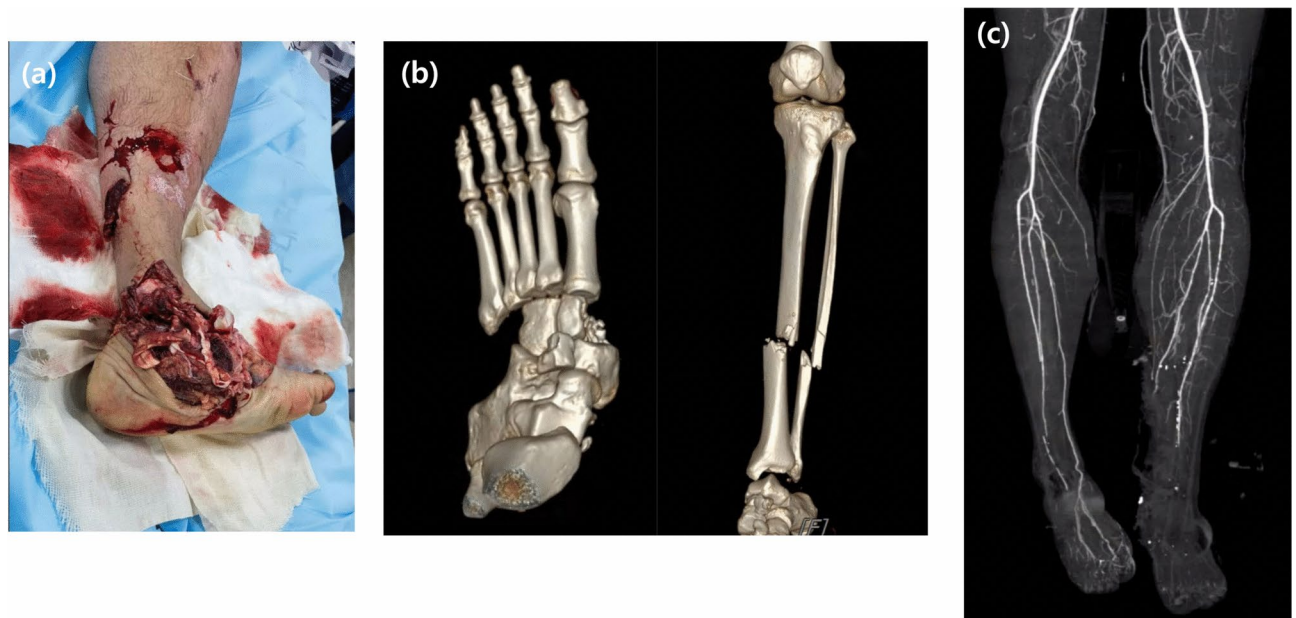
A 35-year-old man presented to the trauma center following a motorcycle collision with a left lower extremity injury. The predicted amputation level was below knee. (a) Left-sided pulseless “mangled” lower leg, ankle and foot injuries. (b) Computed tomography (CT) scan shows left tibiofibular shaft fracture and dislocation of the tibiotalar and Lisfranc joints. (c) CT angiography demonstrates injury of the left dorsalis pedis artery and posterior tibial artery.
